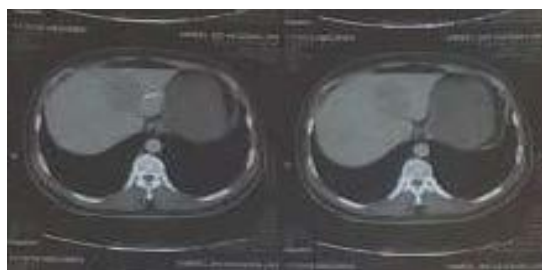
CT scan abdomen triphasic showing hypodense mass lesion in liver on portovenous phase (arrows).
